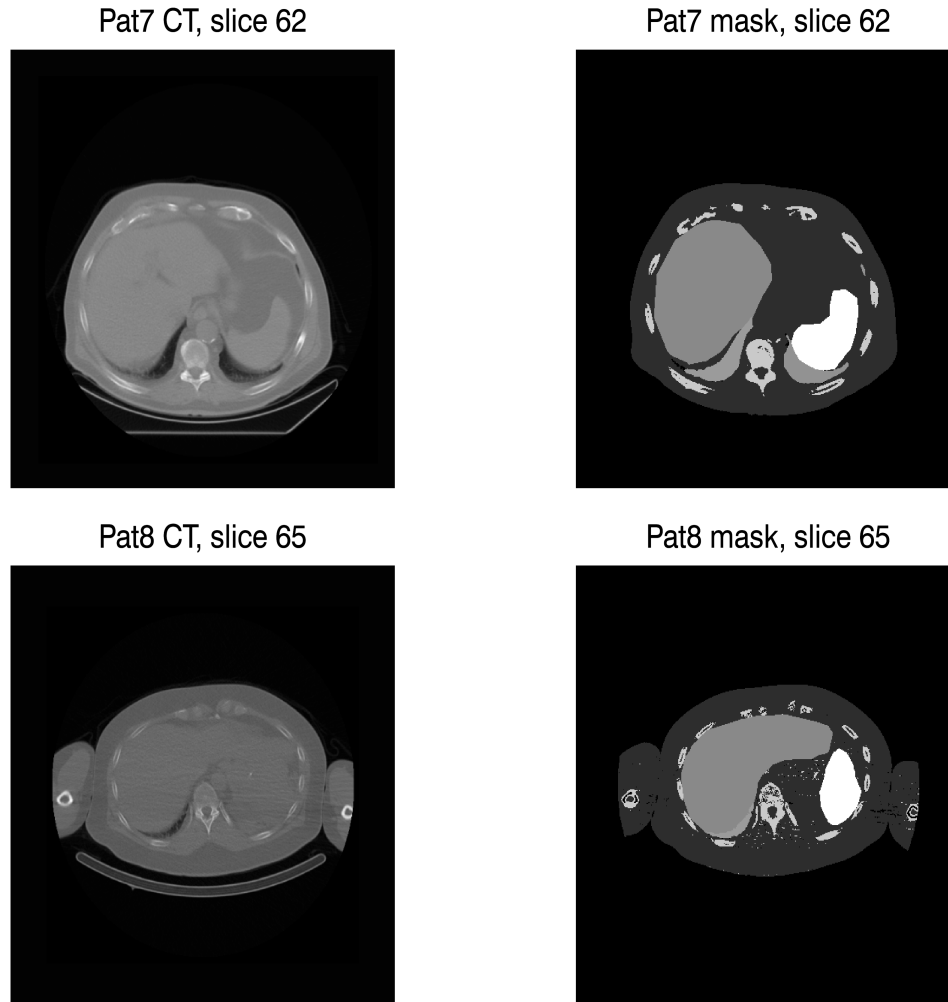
Masks and CT's for patient 7 and 8.
